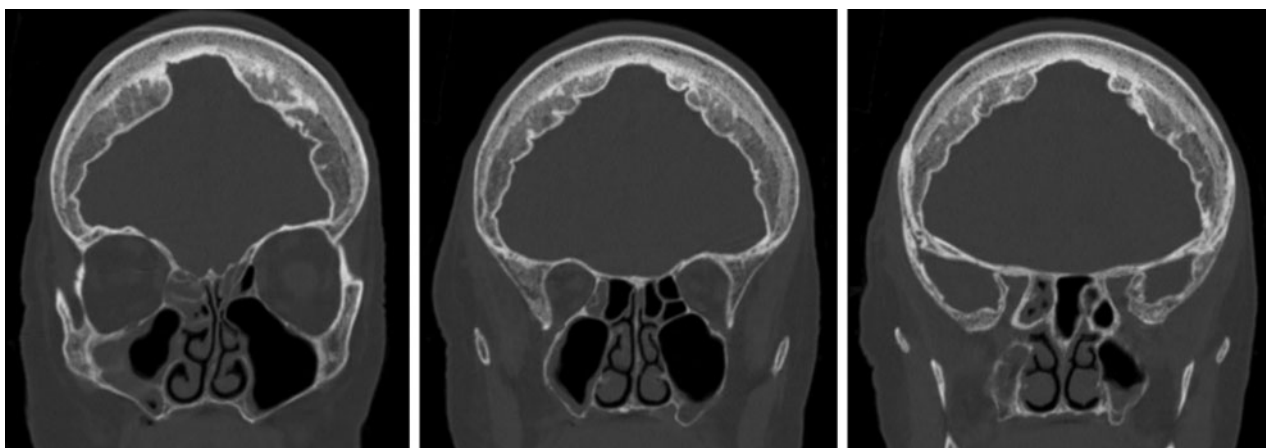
Example of Lund–Mackay sinus scoring. Non-contrast coronal computed tomography images of the head of a patient with a total Lund–Mackay sinus score of 4: partial opacification of left anterior ethmoid sinus (1 point); partial opacification of right maxillary sinus (1 point); partial opacification of right anterior ethmoid sinus (1 point); and partial opacification of right sphenoid sinus (1 point).
